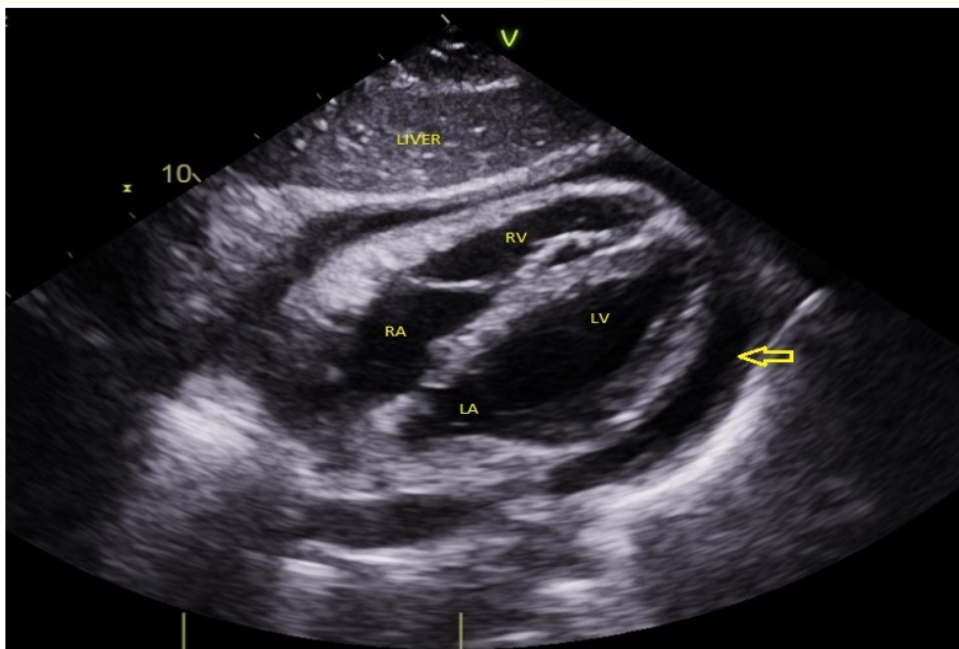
Transthoracic echocardiogram (subcostal view) confirms pericardial effusion (arrow).
